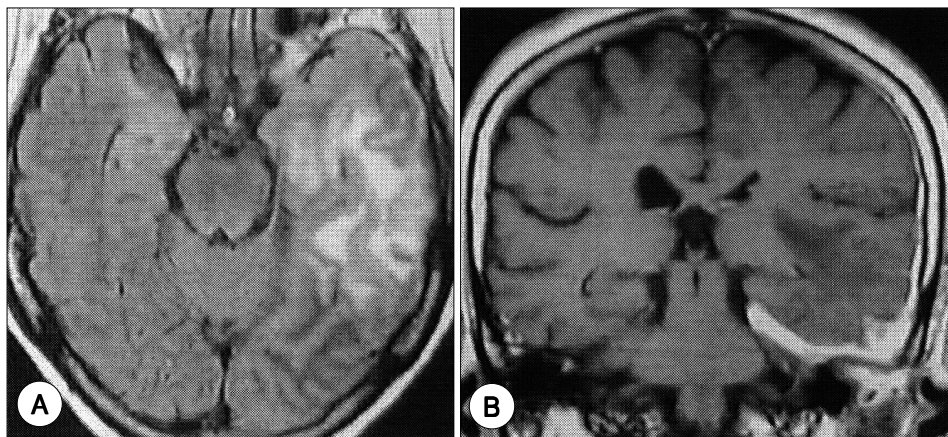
Brain MRI of case 1. A : Non-enhanced FLAIR image revealed high signal intensity lesion involving left basal temporal region. B : Gadolinium enhanced coronal T2-weighted MRI showed strong dural enhancement of left basal and lateral temporal lobe. Note relative sparing of superior temporal gyrus.
